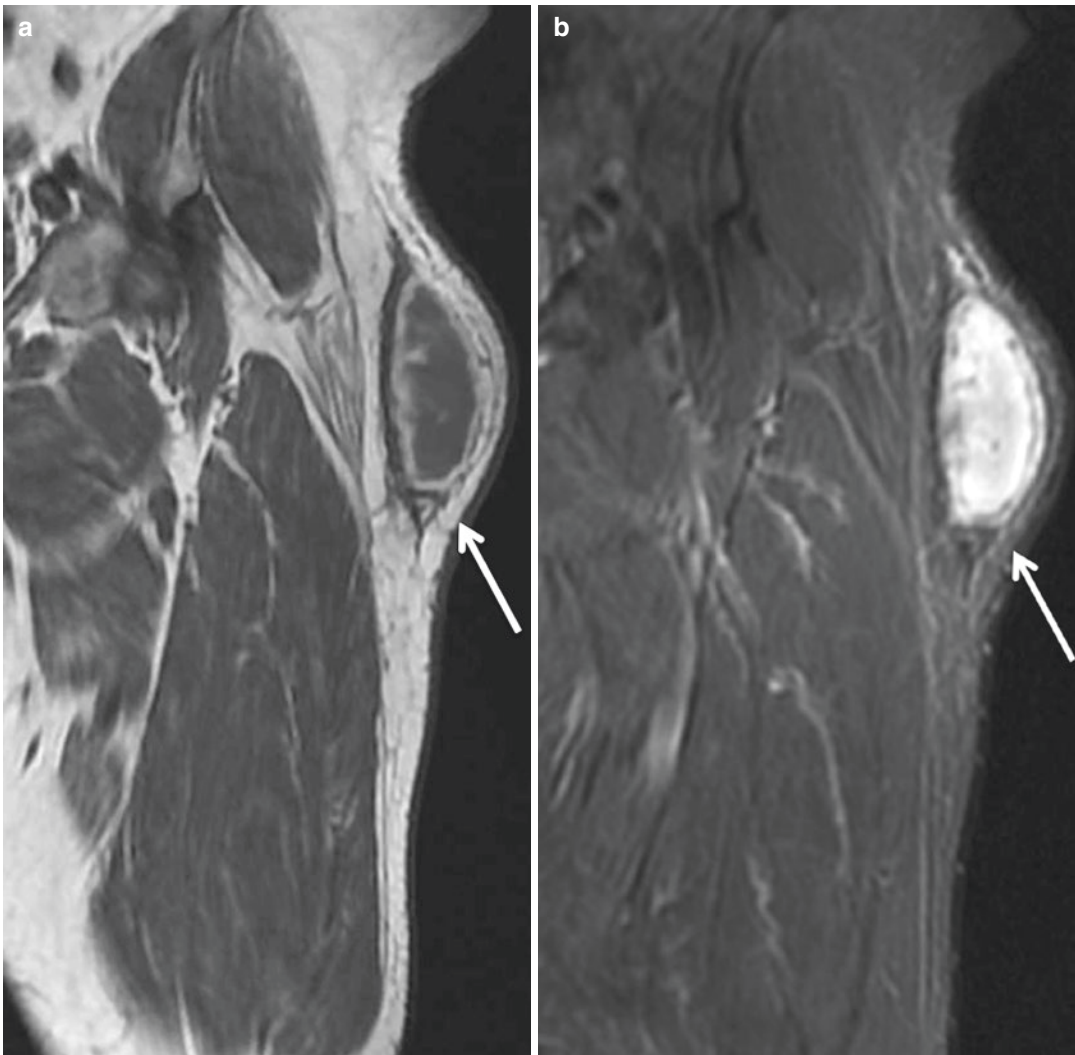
(a) MRI sagittal T1 and (b) MRI sagittal STIR. This lesion is characterized by a filled cystic cavity (*arrow*) created by separation of the subcutaneous tissue from the underlying fascia in classic location over the greater trochanter
